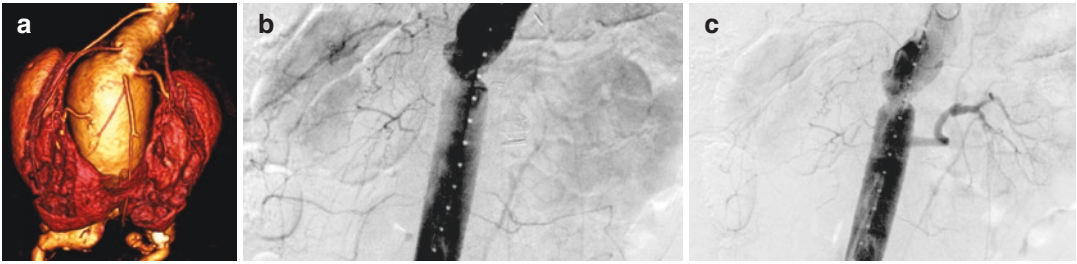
(a) CTA of AAA associated with a horseshoe kidney; (b/c) control angiograms showing the good perfusion of the kidney after OR and renal artery reimplantation
